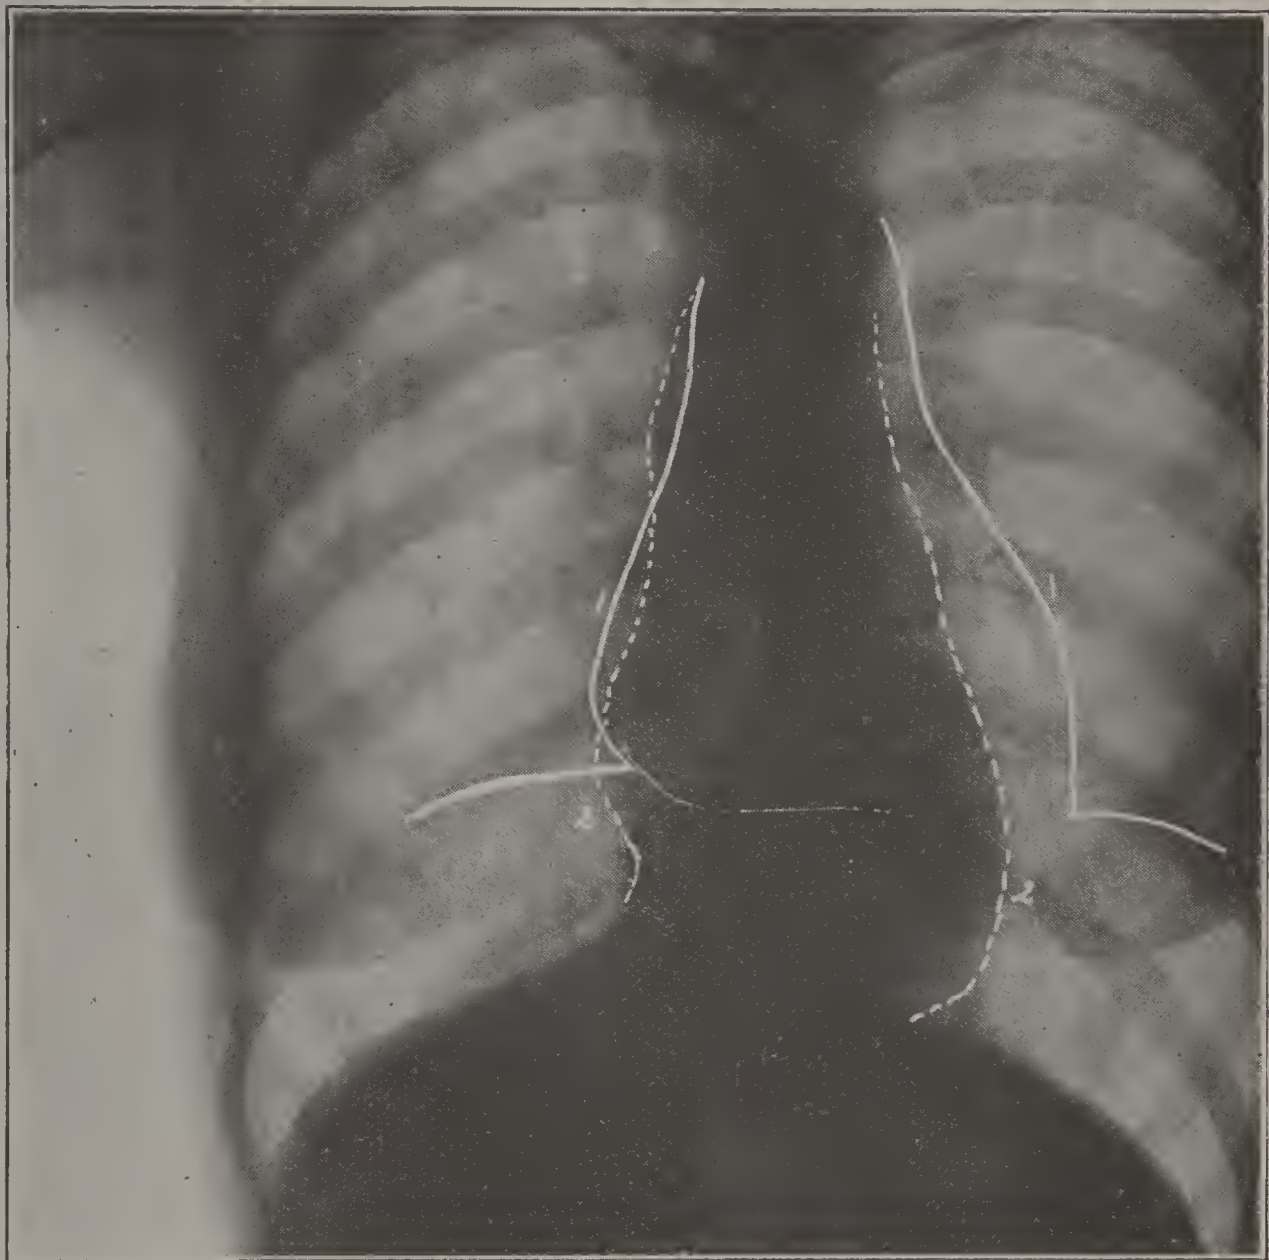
Radiograph taken during forced inspiration.
